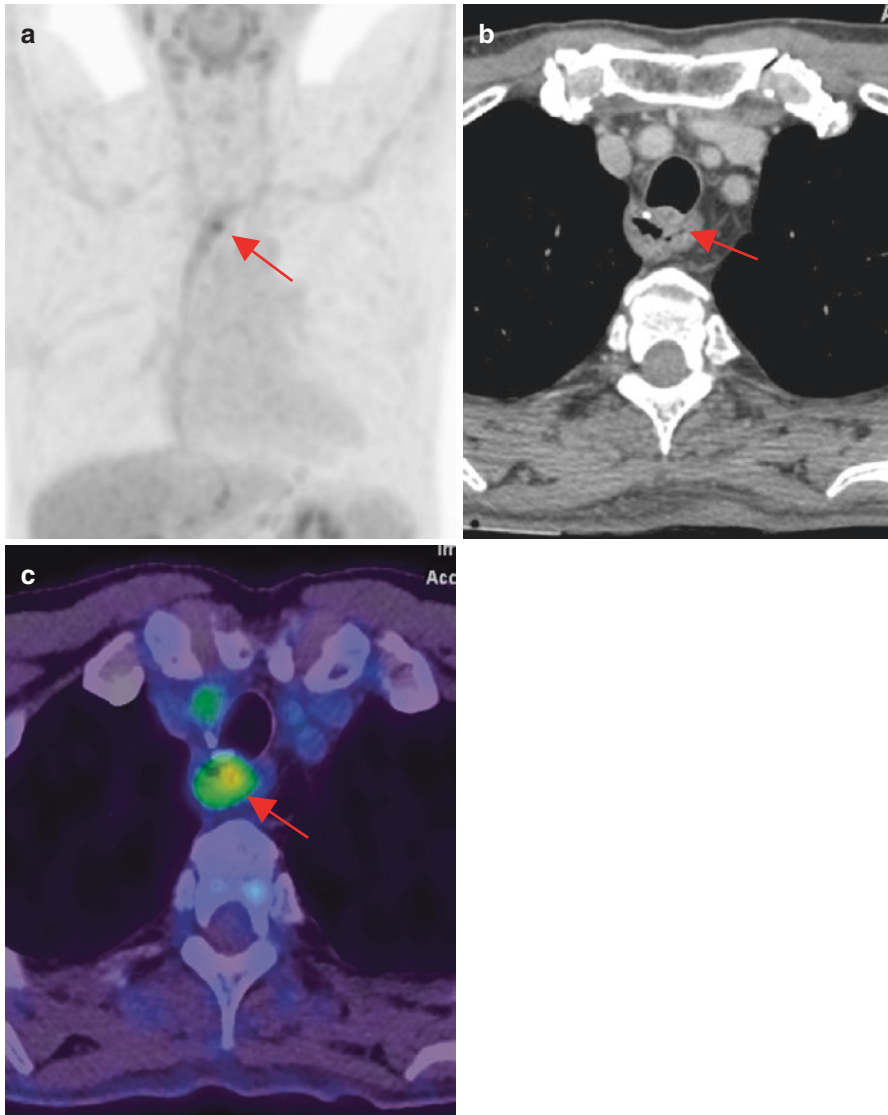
Early detection of local recurrence. (a) A faint FDG accumulation was noted at reconstructed esophagus (arrow). (b) A small nodule was disclosed adjacent to surgical clip though detection may be difficult only by CT. (c) PET/CT fusion image clarified the FDG spot was consistent with the nodule, which was proved to recurrent focus later by biopsy
